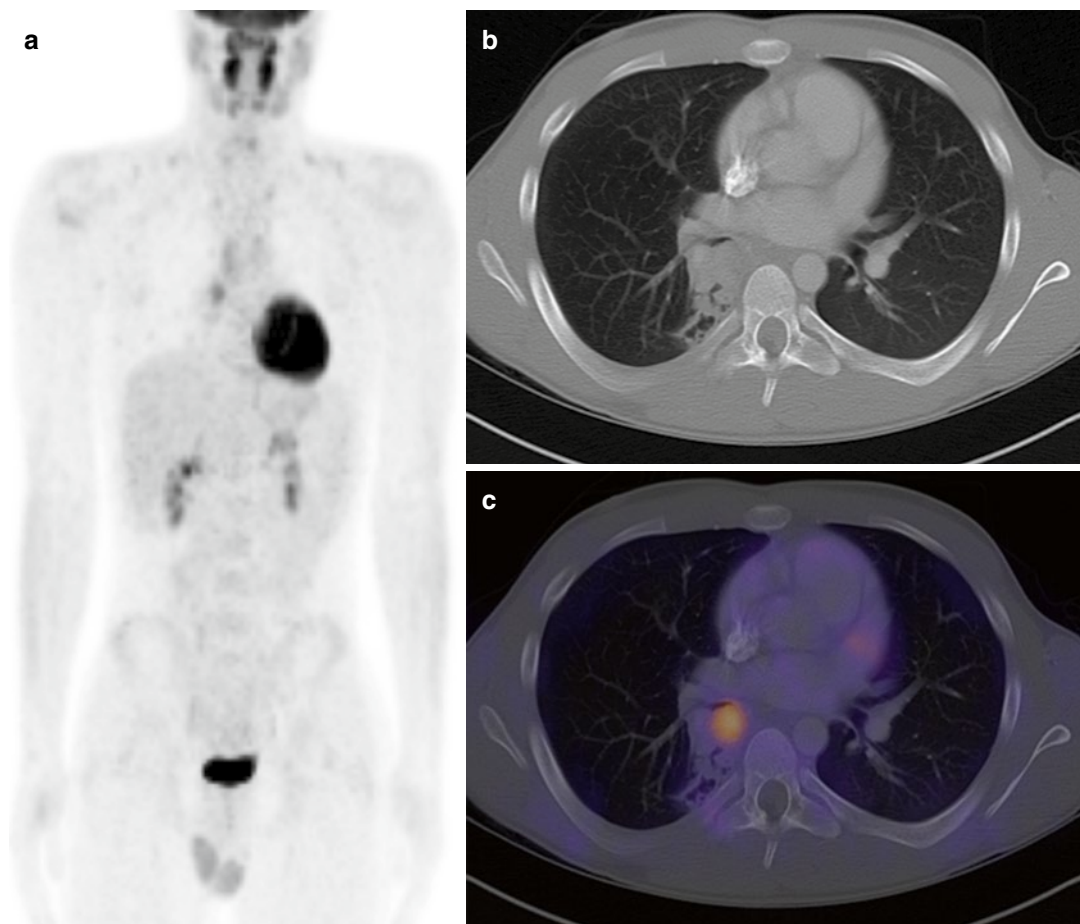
^{18}F -FDG PET of an endobronchial carcinoid. The patient shown in Fig. 20.12 also had an ^{18}F -FDG-PET. (a) The maximum intensity projection image shows mildly increased focal uptake near the right hilum. (b) Chest CT shows a 2 cm mass lesion obstructing the lower
